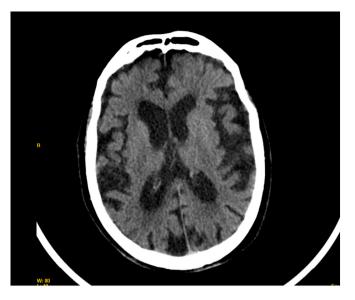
Brain CT scan: diffuse moderate to severe cortico-subcortical brain atrophy is observed, without evidence of acute processes, space-occupying lesions or other alterations.
